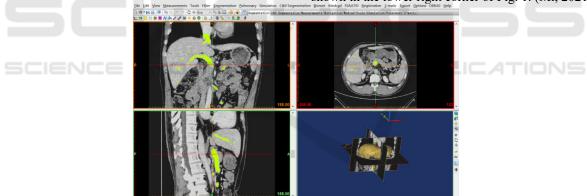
Three-dimensional images reconstructed after the patient CT was imported into Mimics.
